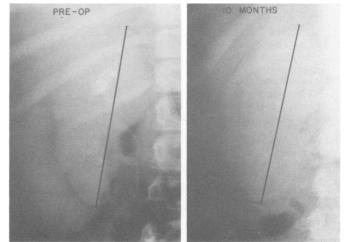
Anteroposterior intravenous urography in Case 4 before and 10 months after end-to-side portacaval shunt. Although the X-ray projections have slight differences, the length of the right kidneys appears to be decreased slightly. The bracket encompasses 12 cm.
